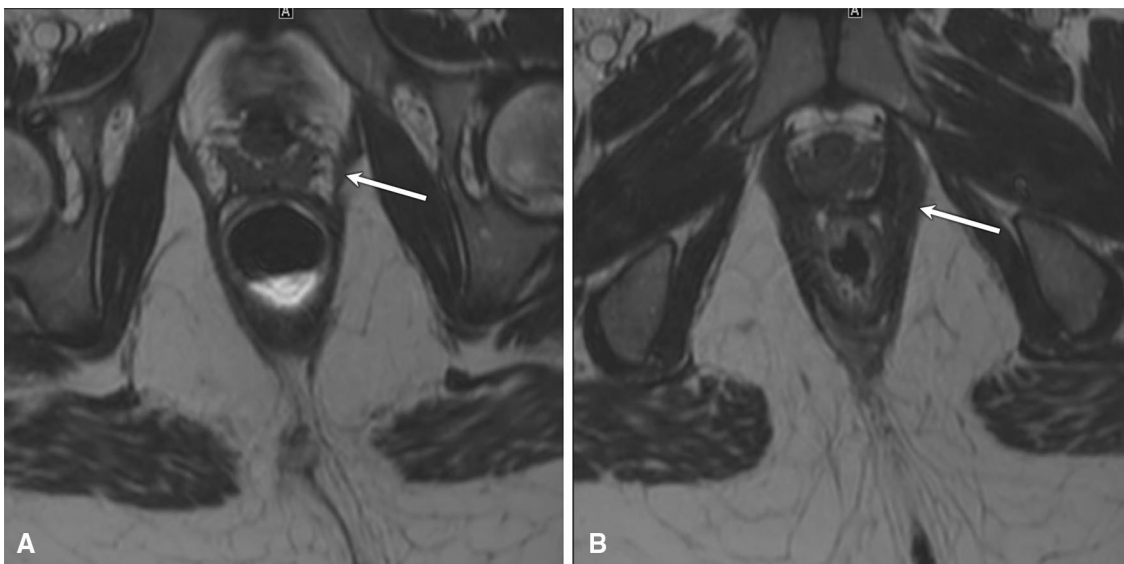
Pelvic floor dyssynergia. Axial high resolution T2-weighted images through the level of pubococcygeus (a) and puborectalis (b) demonstrate diffuse thickening of puborectalis (b, arrow), greater than three times the thickness of pubococcygeus (a, arrow)
